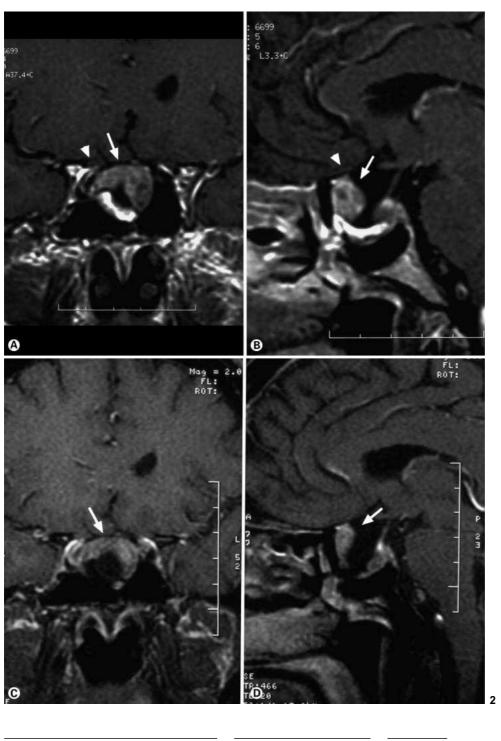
A 63-year-old presented with bilateral temporal hemianopsia. A pituitary adenoma was discovered and the patient underwent transsphenoidal surgical resection. Four years later, MRI imaging showed a recurrent tumor (arrow) adjacent to the optic nerve (arrowhead), as shown on coronal (A), and sagittal (B) MR contrast-enhanced images. The patient was treated with the Cyberknife using 2 fractions for a total of 18 Gy. At one year follow-up the tumor (arrow) was smaller on both coronal (C) and sagittal (D) MRI contrast images, and the patient's vision remained normal.
